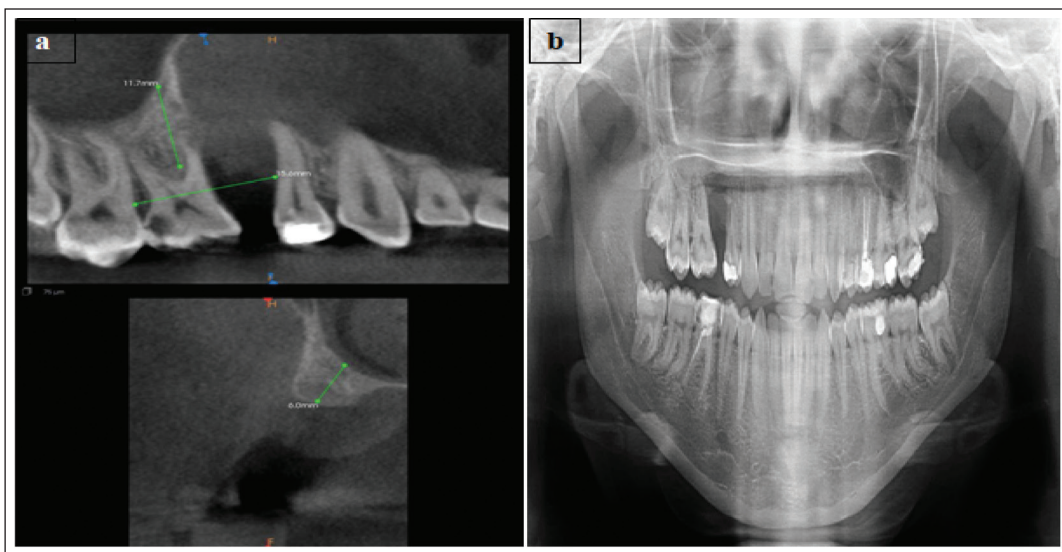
A CBCT shows a severe vertical alveolar bone loss class II from Seibert's classification.
